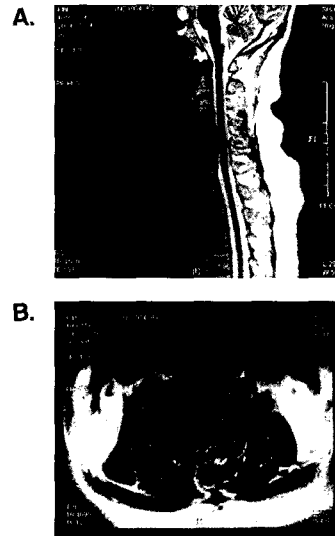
MRI of cervical spine, performed 24th Aug., 2001.
